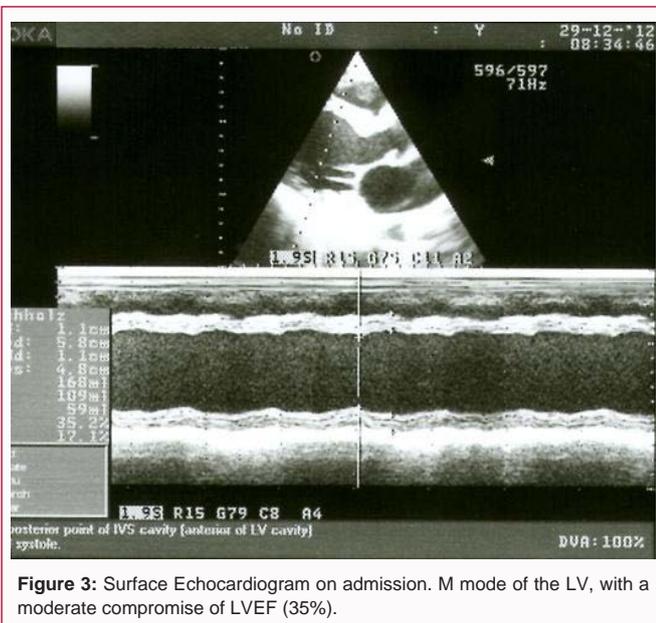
Surface Echocardiogram on admission. M mode of the LV, with a moderate compromise of LVEF (35%).
